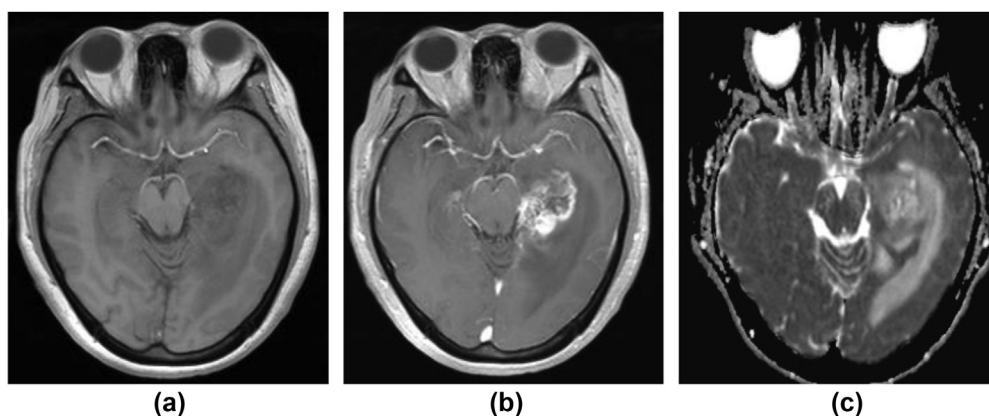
A 49-year-old female with left temporal anaplastic astrocytoma. (a) axial T1-weighted image shows an well-defined heterogenous mass with slightly low signal intensity. (b) post-contrast axial T1-weighted image shows partly obvious contrast enhancement (Proportion non-enhancing = 4); (c) axial ADC map shows that there is no obvious restricted diffusion (ADC-Entropy = 5.050)
